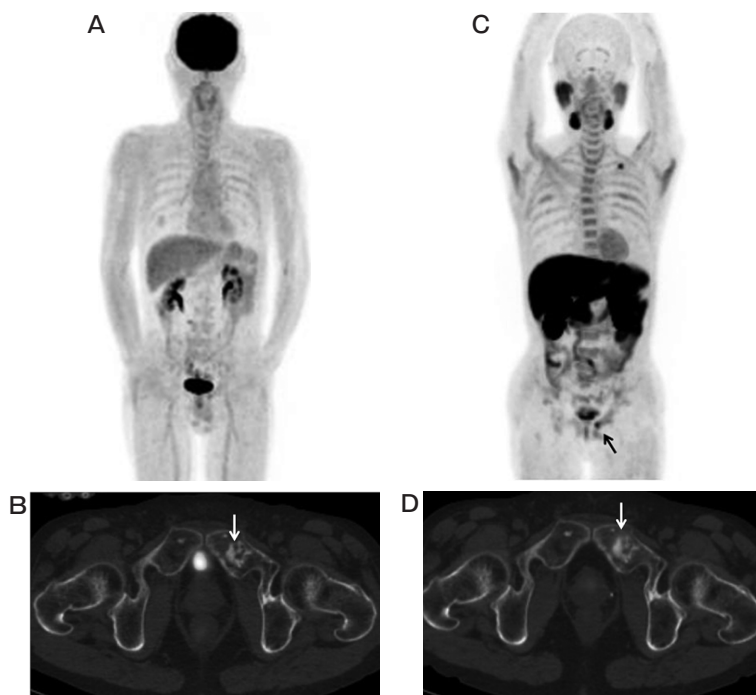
A 69-year-old man with a PSA level of 4.52 ng/mL who underwent androgen-deprivation therapy for prostate cancer (cT3N1M1, initial PSA 221 ng/mL), in whom bone metastasis was found; A, MIP from FDG PET showing no abnormal findings; B, FDG-PET/CT image showing no abnormal FDG uptake in the region of osteoblastic change in the left pubic area (arrow) at the same level as D below, suggesting an absence of viability; C, MIP from ^{11}C -choline PET showing 2 abnormal ^{11}C -choline uptake spots in the left inferior clavicular and left pubic (arrow) areas. The abnormal uptake in the left inferior clavicular area was thought to be physiological uptake pooled in the left subclavian vein; D, ^{11}C -choline PET/CT image showing moderate ^{11}C -choline uptake (SUVmax 4.45) in the region of osteoblastic change in the left pubic area (arrow), reflecting active bone metastasis.
